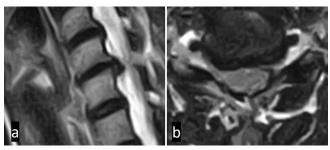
Postoperative cervical magnetic resonance imaging (MRI). (a) Sagittal T2-weighted MRI shows the complete removal of the herniated fragment. (b) Axial T2-weighted MRI shows sufficient nerve root decompression.
